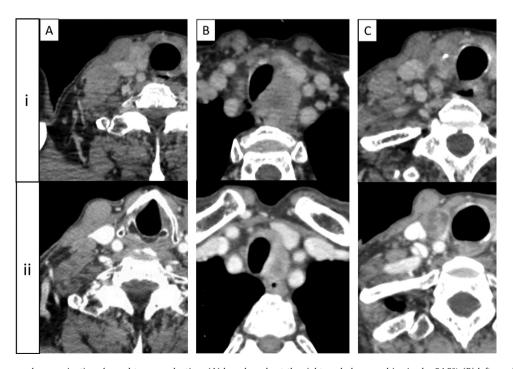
A computed tomography examination showed tumor reduction: (A) lymph node at the right neck decreased in size by 84.3%, (B) left parabronchial lymph node decreased in size by 56.0%, and (C) thyroid tumor decreased in size by 5.9%. (i) before treatment, (ii) after treatment.
